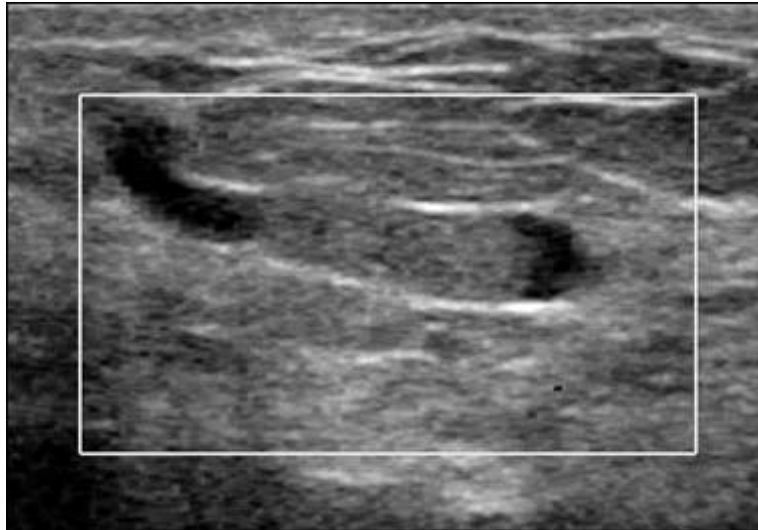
A 62-year-old female presented for check-up. Sonography revealed a single dilated duct with an intraductal nodule at subareolar area of right breast. No intralesional vascularity is seen. Excision confirmed intraductal papilloma.
